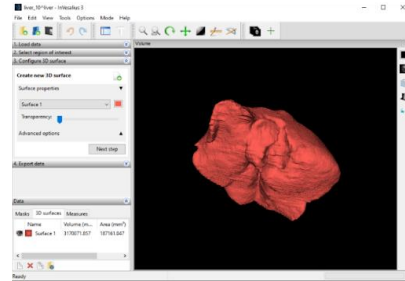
Reconstructed 3D generic model from 2D CT scans using INVESALIUS 3.
